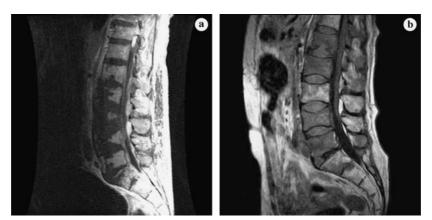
(a, b) T1 and T2 sequences of a sagital MRI scan of the LS spine, showing the tumor involvement of the bone marrow.
